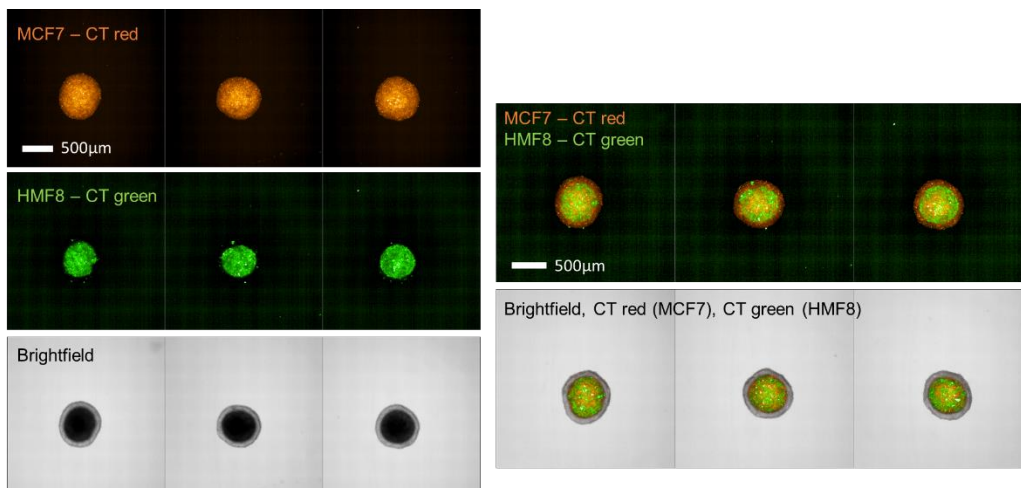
Heterotypic spheroids obtained by the co-culture between 5,000 cells of MCF7 cell line (CellTracker™ Red CMPTX) and 5,000 cells of fibroblasts HMF8 (CellTracker™ Green CMFDA). Images represent CT red maximum intensity projection (left-top), CT green maximum intensity projection (left-middle), brightfield (left-bottom) and merges of CT green + CT red maximum intensity projections (right-top) and merge of all channels (right-bottom) acquired by Operetta CLS™ 72h after seeding.
